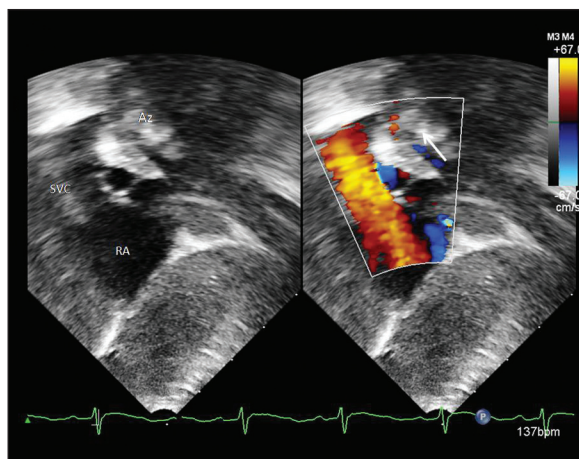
Post-natal echocardiography sub-xiphoid view showing a dilated SVC with the venous channel (azygos vein) running parallel to the descending aorta (arrow) and joining the SVC. SVC = superior vena cava; RA = right atrium; Az = azygos vein
